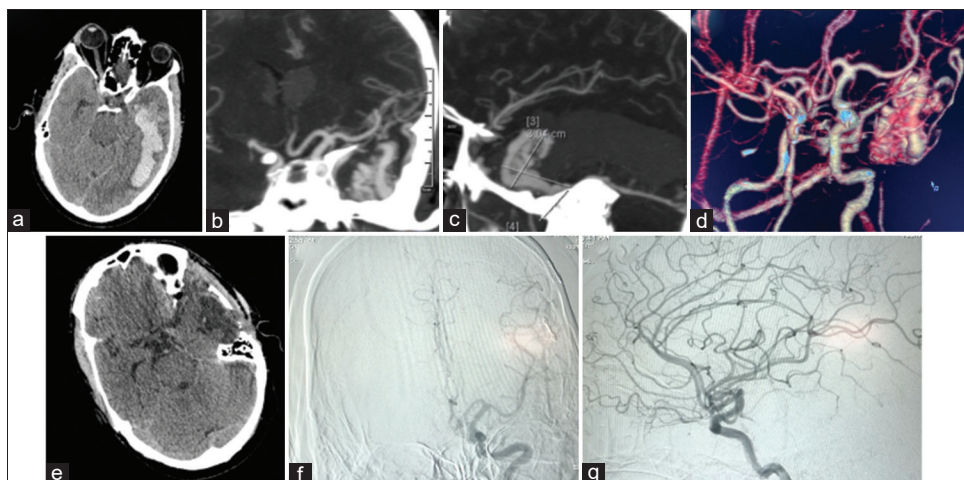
Left temporal arteriovenous malformation of SMG IV and supplemented SMG 7. (a) Plain computed tomography scan axial showing evidence of left temporal hematoma. (b) Computed tomography angiogram coronal view with intravenous contrast showing arteriovenous malformation with feeder from left middle cerebral artery. (c) Computed tomography angiogram sagittal view with intravenous contrast showing arteriovenous malformation with feeder from left middle cerebral artery. (d) Three-dimensional computed tomography angiogram coronal view with intravenous contrast showing arteriovenous malformation with feeder from left middle cerebral artery. (e) Postoperative plain computed tomography scan showing complete excision of left temporal arteriovenous malformation. (f) Postoperative digital subtraction angiography coronal showing normal left cerebral vasculature and no evidence of abnormal vessels. (g) Postoperative digital subtraction angiography sagittal showing normal left cerebral vasculature and no evidence of abnormal vessels
